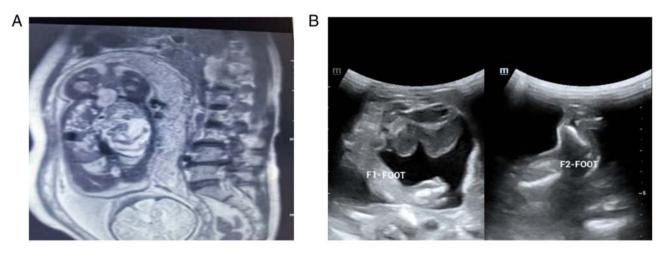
MRI of FIF. (A) MRI image of the fetus showed signals of a long bone in a retroperitoneal cystic mass of the host fetus. (B) After the delivery of the fetus, US showed retroperitoneal twin FIF in the host fetus. MRI, magnetic resonance imaging; US, ultrasonography; FIF, Fetus in fetu.
